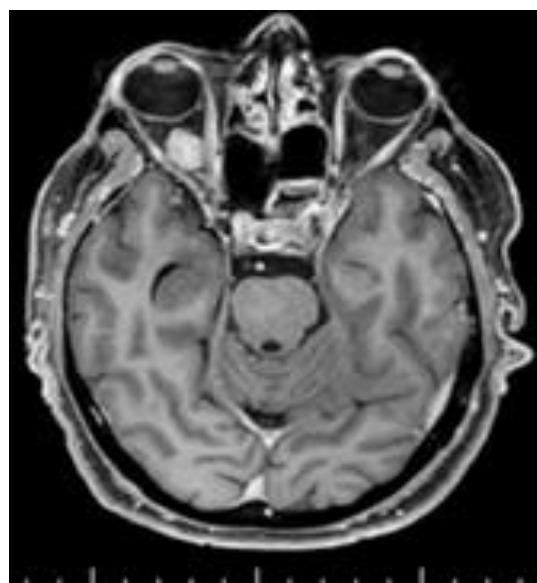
MRI of the patient showing well defined lesion in the intra-conal compartment lateral to and indenting on the optic nerve causing its lateral displacement
